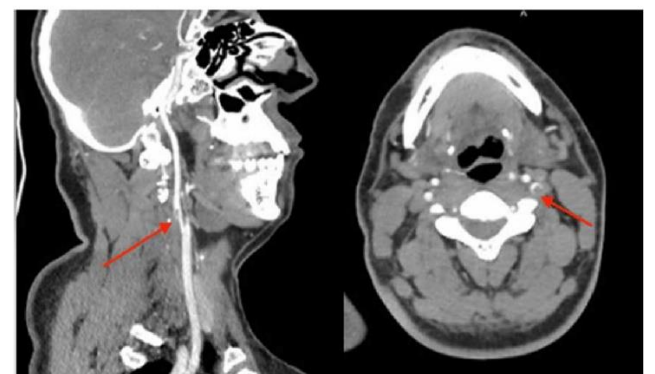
Cervical contrast-enhanced computed tomography
